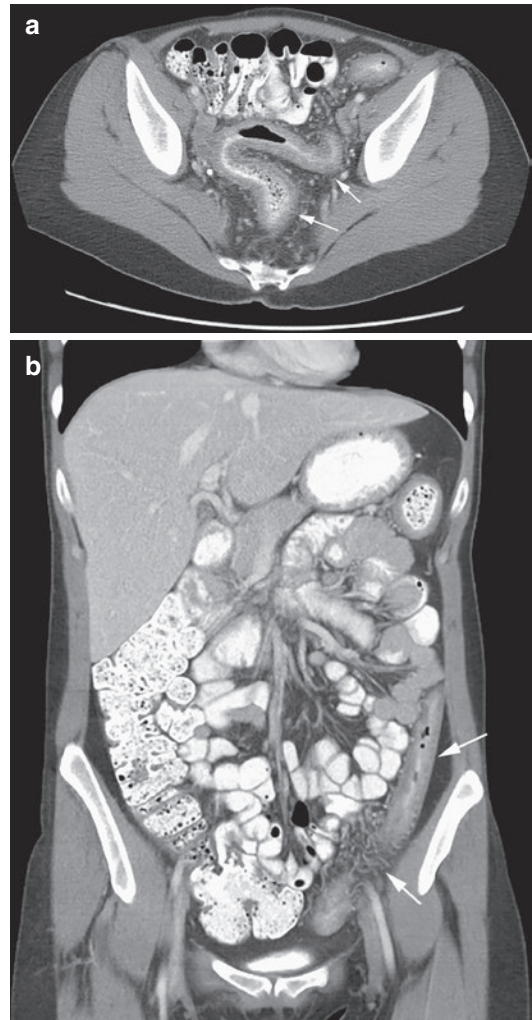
A 23-year-old with history of ulcerative colitis presents with worsening abdominal pain and diarrhea. (a) Axial CT following intravenous and oral contrast administration demonstrates marked contiguous rectosigmoid wall thickening, and (b) coronal reformatted images demonstrate continuity to the level of the descending colon with engorgement of mesenteric vessels (arrows)
